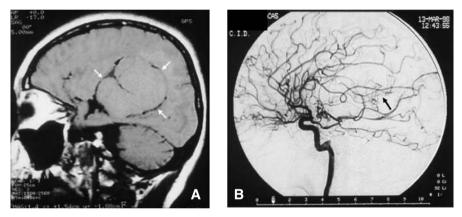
Meningioma of the atrium. A MRI showing a large tumor (*arrows*). B Carotid angiogram demonstrating feeding from the posterior choroidal arteries (*arrow*)
